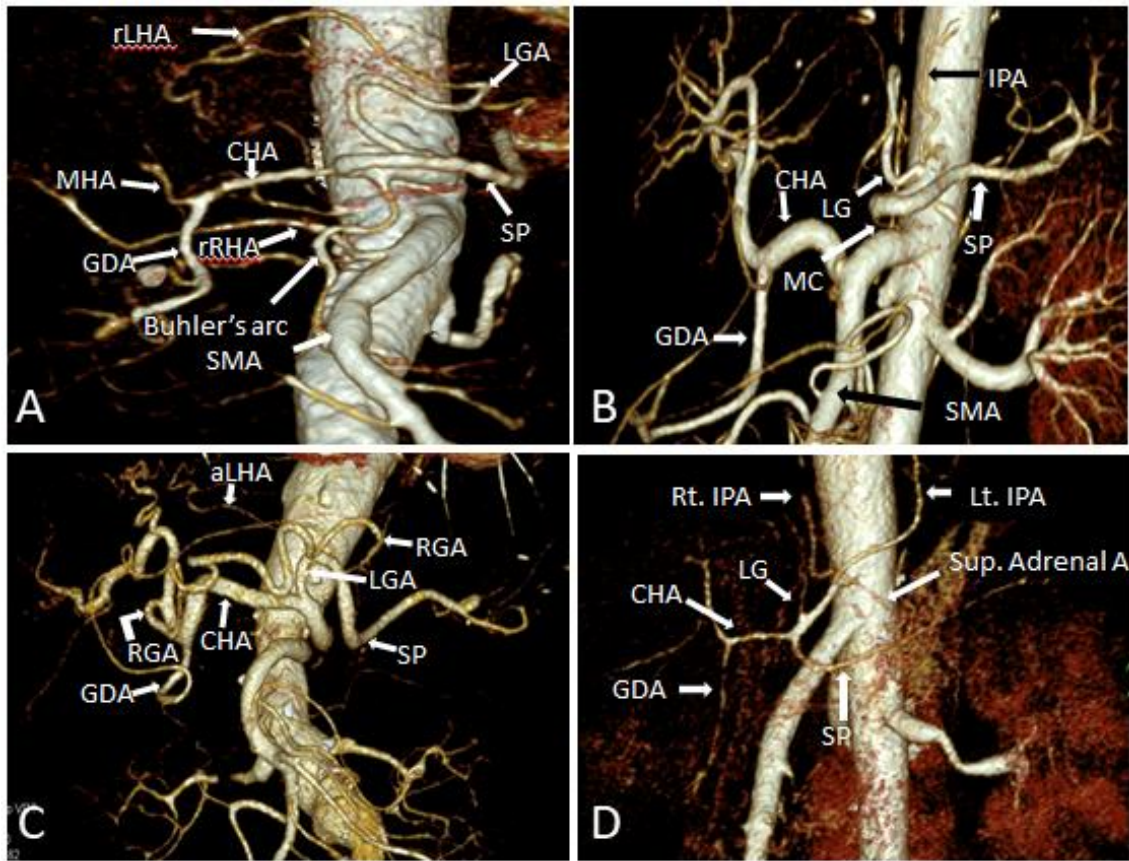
3D VR images (A) Shows Buhler's arch which connects the CT with the SMA and represent qudrifurcation of the CT, where the rLHA arises from the LGA and rRHA arises from SMA and the MHA is a branch of CHA. (B) Bifurcation of CT as gastro-splenic trunk where the IPA as a variant branch of the CT. CHA originates from SMA as hepato-mesenteric trunk. (C) Shows Hepato-splenic trunk (Uflacker's type II), where the LGA is originated from the SP artery. The RGA arises from the proper hepatic artery and gives off aLHA. (D) Shows Hexafurcation of the CT with normal trifurcation along with another trifurcation where both IPA and left superior adrenal artery originate with a common trunk from the celiac trunk.
